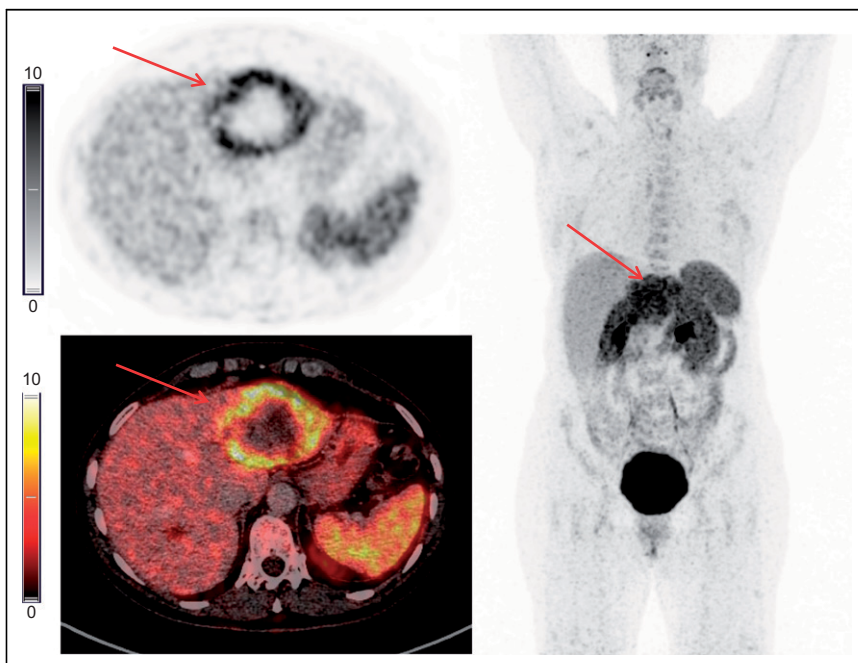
Example of ^{68}Ga -NODAGA-E[c(RGDyK)]₂ PET/CT. Transaxial PET and fused PET/CT and maximum-intensity projection with color bars (unit: SUV). Patient with gastric NET grade 2 (Ki-67 8%) with liver metastases. Arrows point to liver metastasis.
